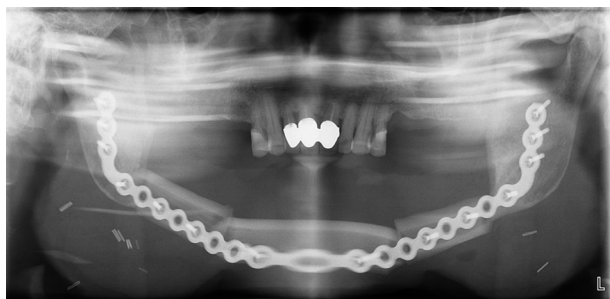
Postoperative panoramic radiography showing reconstructed mandible from mandibular angle to angle.
